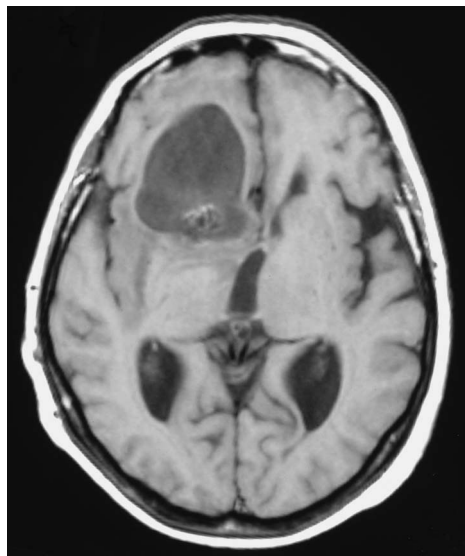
A 3-month postoperative magnetic resonance image showing an expansive process around the coiled aneurysm (axial section).
